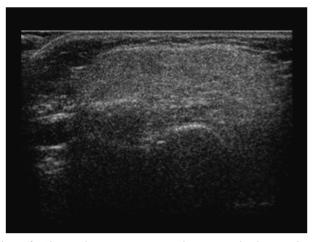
Abnormal transverse axis quadriceps muscle ultrasound in a child with Duchenne muscular dystrophy; diffuse fibro-fatty tissue replacement in this disorder is shown with increased echogenicity, leading to a "ground glass" appearance.
